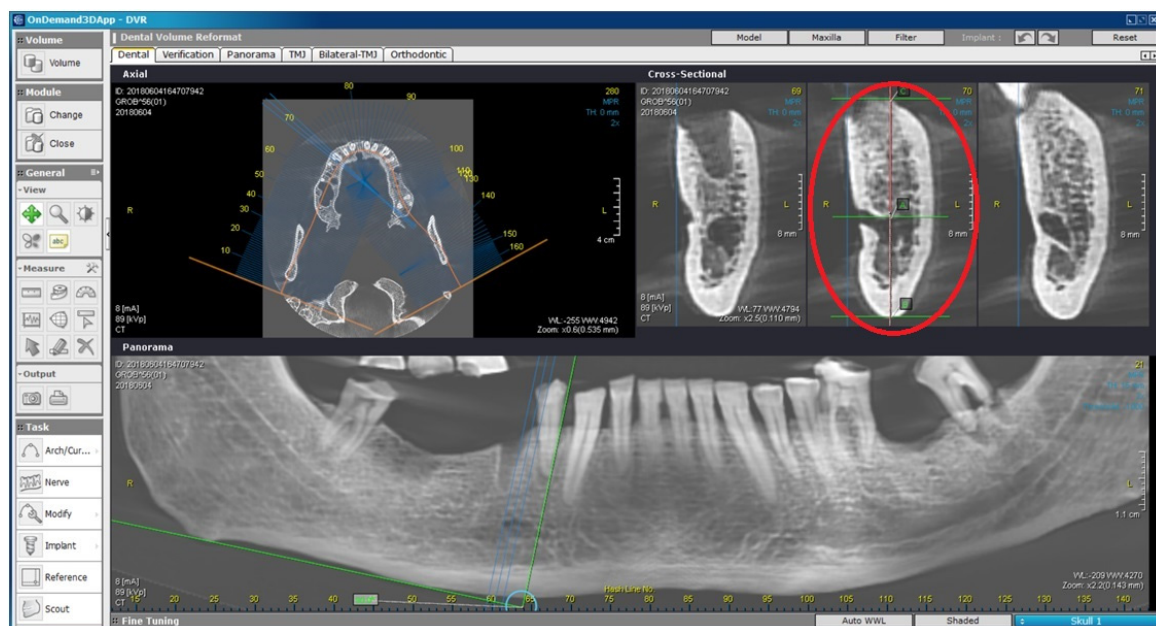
Measurement of the level of resorption of the alveolar ridge (M/M) on the CBCT scan. The M/M was calculated as the ratio between the total height of the mandible (BC) and the distance between the center of the mental foramen and the lower edge of the mandible (AB) (circled in red). $M/M = BC/AB$.
